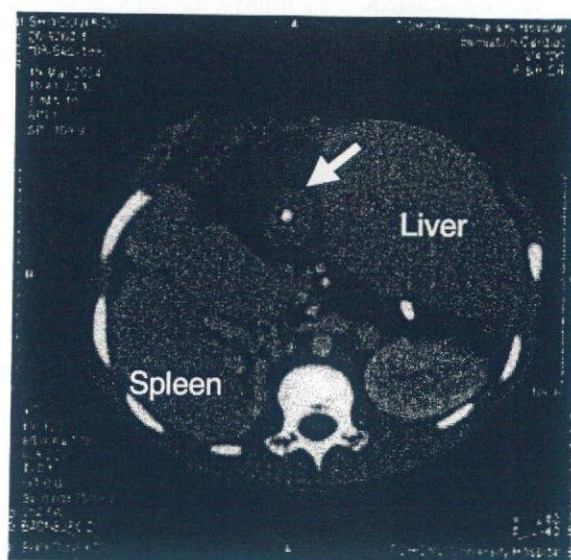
Computed tomography of a dilated jejunal loop containing a biliary stone around stent tube (arrow head).
